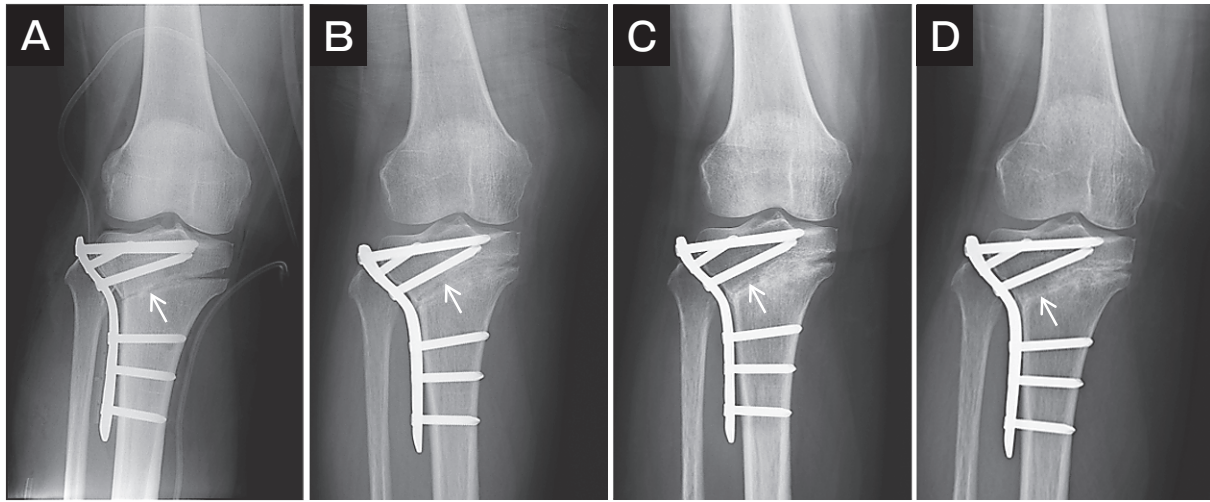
Postoperative radiographs. (A) Postoperative day 0. Fifteen degrees of correction. Hinge point, 2 : 1. Radiographic images at 2 (B), 4 (C), and 6 months (D) postoperatively. Arrow indicates osteotomy line.
